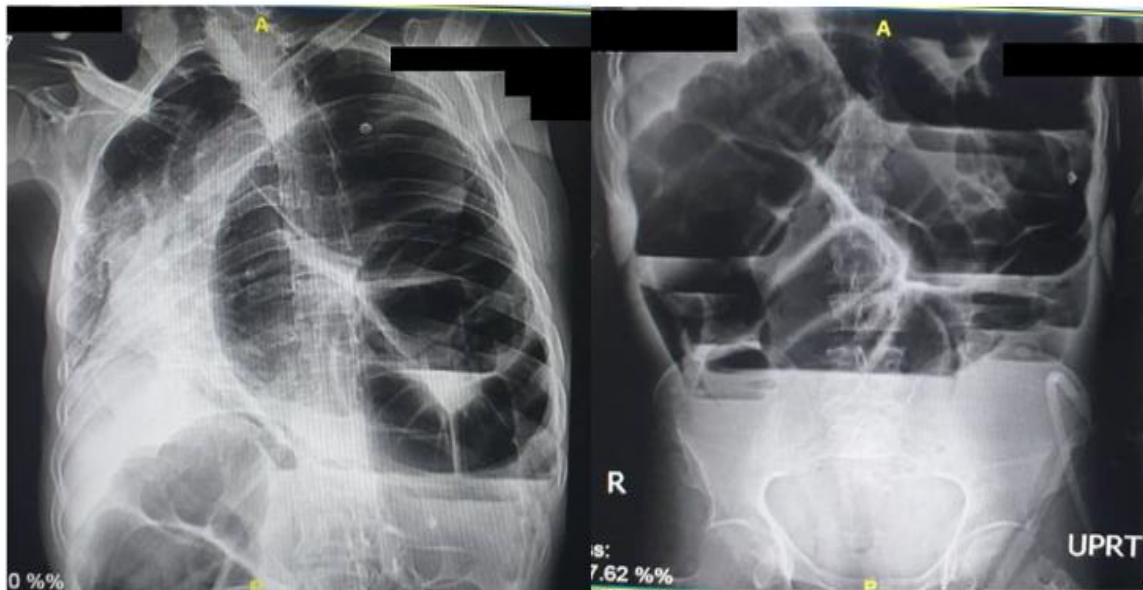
Left: chest radiograph showing the colon herniated into the thoracic cavity, cardiac and mediastinal shift, and left lung collapse. Right: abdominopelvic radiograph showing dilated loops of the bowel.
